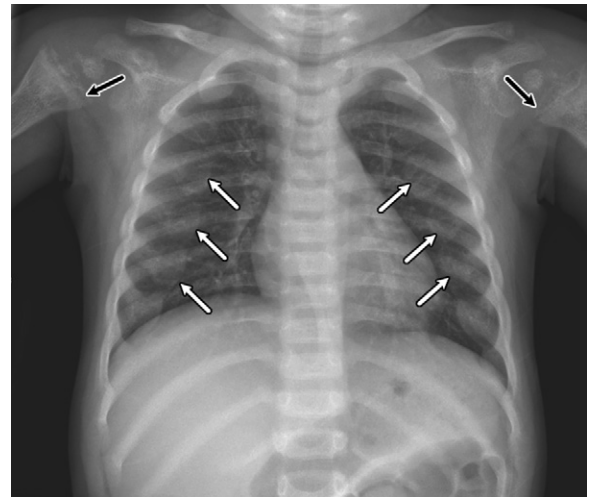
Rachitic rosary in a 1-year-old boy with vitamin D deficiency. Frontal chest radiograph shows bulbous enlargement of the costochondral junction (white arrows) and rachitic changes of the proximal humerus (black arrows) due to excessively undermineralized osteocartilaginous matrix.
